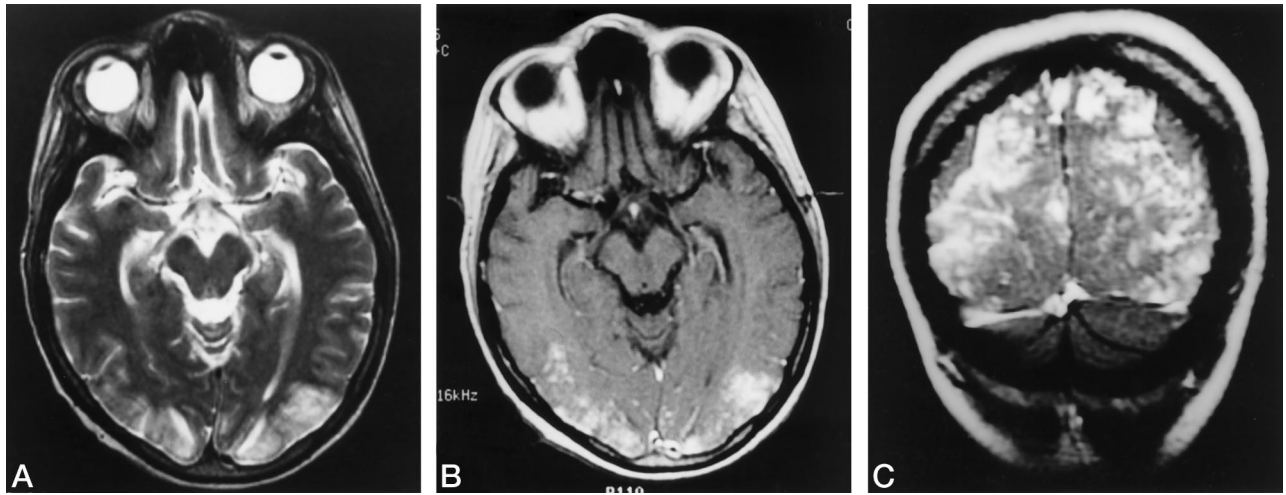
Patient 8: 16 days after transplantation. Axial T2-weighted (4300/102/2) image (A) and axial (B) and coronal (C) contrast-enhanced T1-weighted (600/23/1) images show bioccipital T2 hyperintense signal and extensive enhancement.
